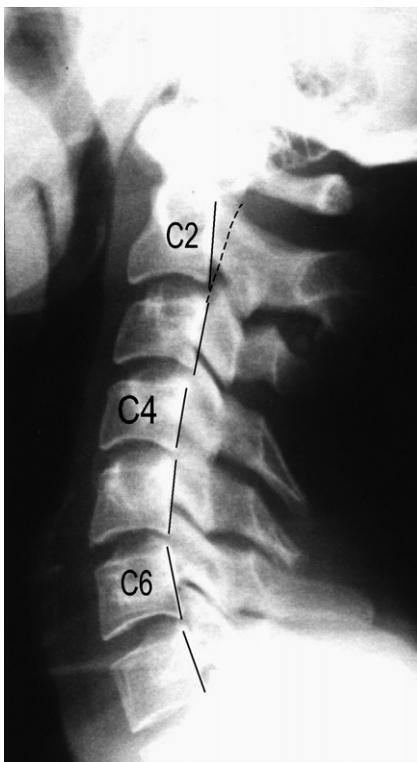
Cervical spine lateral plain X-ray image. Note the loss of normal cervical spine lordosis in the upper cervical spine (C1–C3 region) where there is a tendency towards a kyphosis of the spine above C4. The broken line represents what would be a more normal continuation of the lordotic curve in a normal spine.
